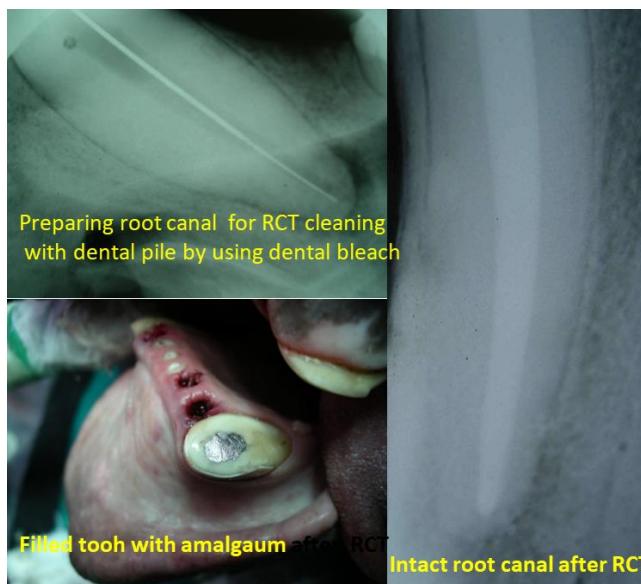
Dental Radiographic examination of the bear
